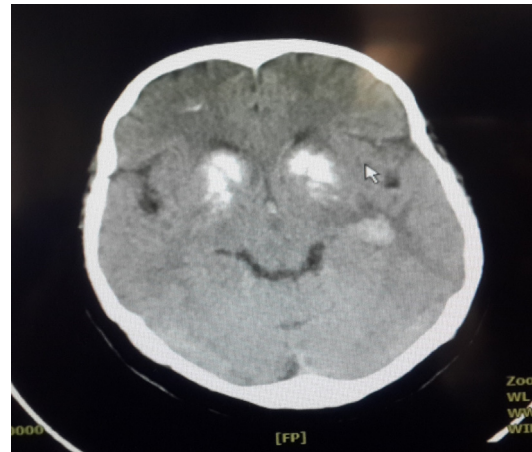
Her brain CT scan
